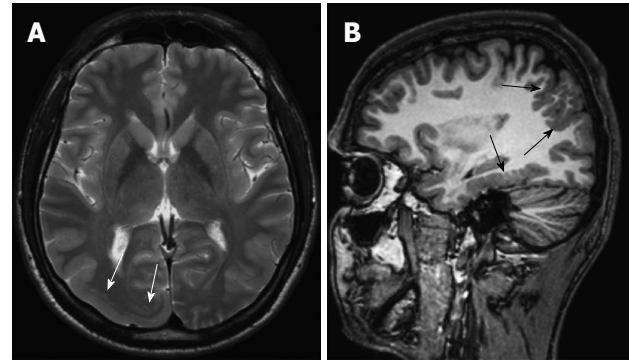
An 18-year-old boy with cobblestone lissencephaly. Axial T2-weighted image (A) shows incomplete lissencephaly in right occipital region (white arrows). Sagittal 3D T1-weighted image (B) reveals multiple areas of shallow microgyri (black arrows) in the parietal and temporal lobes.
